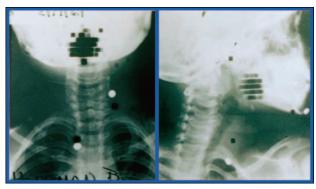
Fusion imaging is not a recent innovation. Half a century ago at the author's institution the distribution of radionuclide activity was routinely superimposed on standard radiographs. Here, the rectilinear image of the distribution of radioactive iodine at the base of the patient's tongue and lack of accumulation in the neck indicated the presence of a sublingual thyroid, information that facilitated avoidance of unnecessary surgery.
